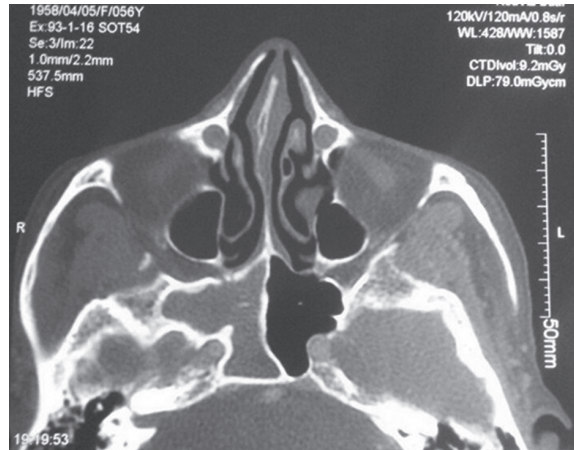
CT-scan showing a tumoral solid mass at anteroinferior of the right nasal cavity.
